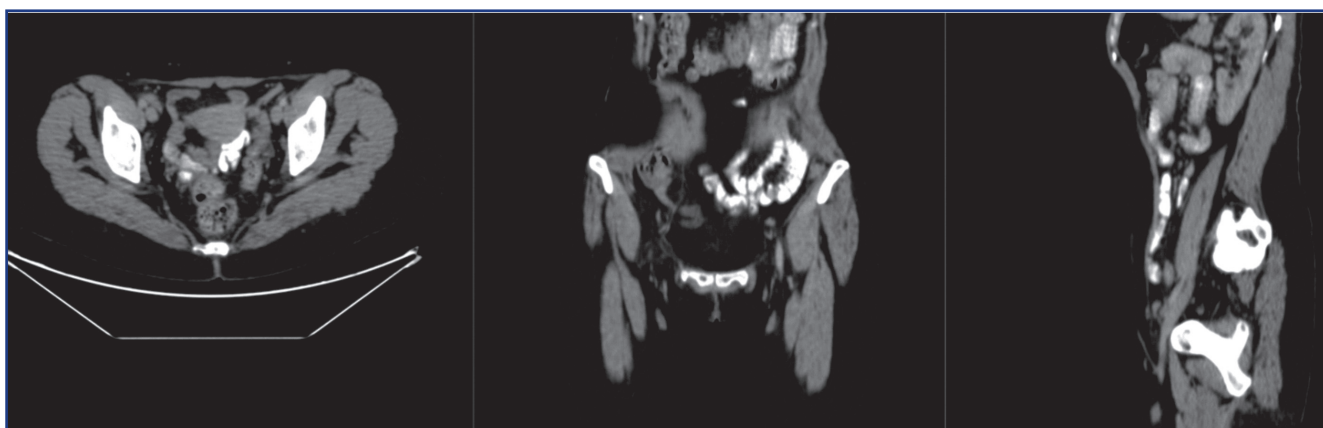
CT of the chest, abdomen and pelvis with intravenous contrast on November 07, 2022
